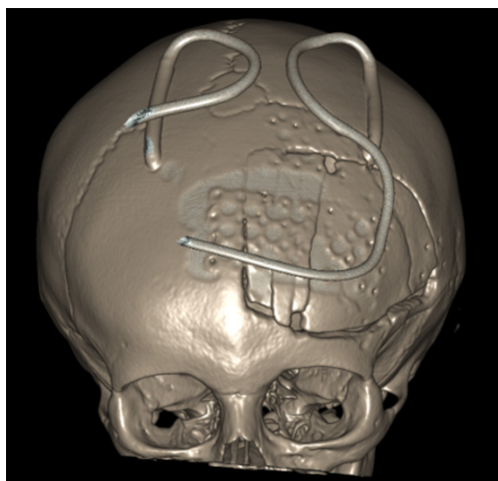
Postoperative computed tomography of 3-dimensional reconstruction with bilateral external ventricular drains with bioabsorbable plating system seen.
